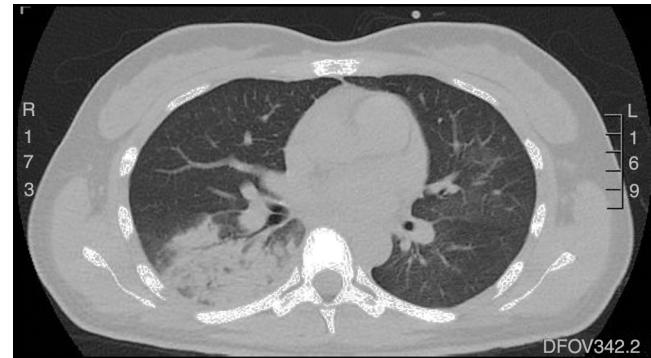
Chest computed tomography showing right lower lobe consolidation.
